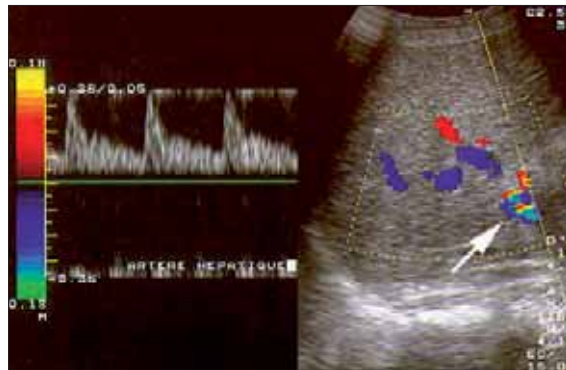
Normal hepatic artery flow measured by Doppler ultrasonography
